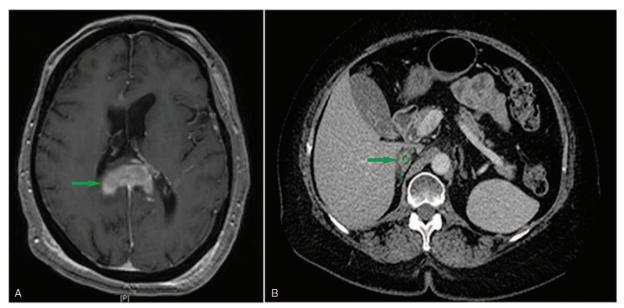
A, Magnetic resonance imaging (MRI) image showed the enhancing mass within the posterior body and splenium of the corpus callosum measuring $3.2 \times 1.4 \times 1.0$ cm, marked with green arrow. B, Computed tomography (CT) image showed the right adrenal nodule measuring 2.1×1.7 cm, marked with green arrow.
